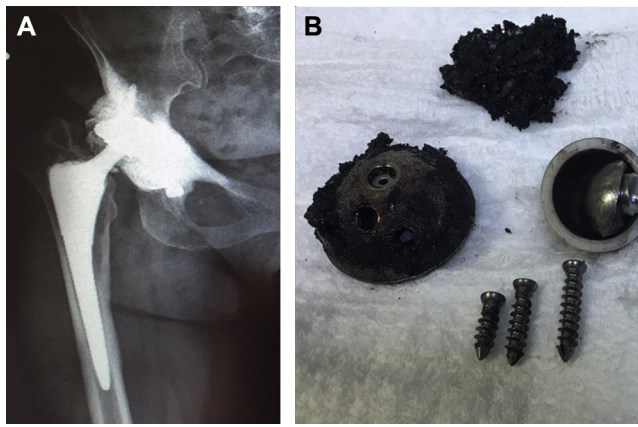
A 55-year-old female who underwent right total hip arthroplasty seven years ago complained of left hip squeaking for four months. A. At seventh years' AP radiography showing metallosis around cup. B. During revision; extracted cup, ceramic liner and debris bony material.
